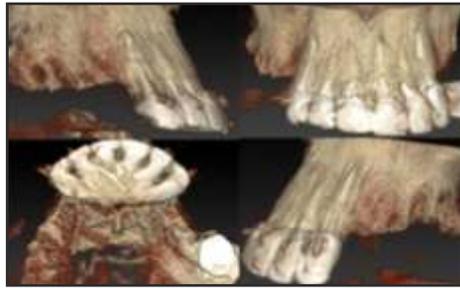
CBCT generated 3D image of maxilla
